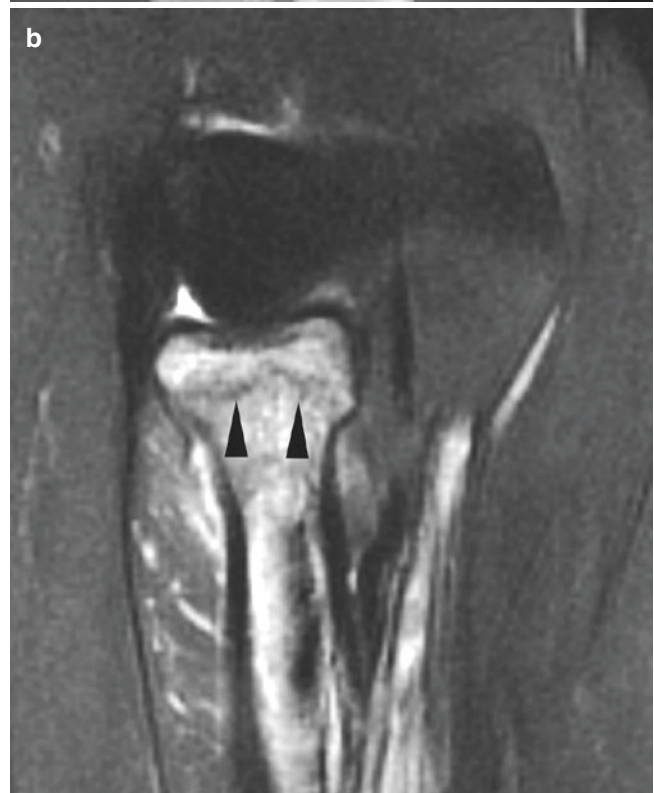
Radiographically occult fracture. (a) Oblique radiograph of the elbow shows no evidence of fracture. (b) Coronal fat-saturated T2-weighted image reveals a non-displaced fracture of the radial head (arrowheads) with surrounding marrow edema. Used by permission of Springer Nature
